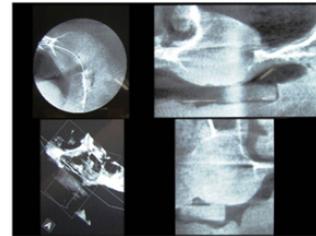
CBCT shows axial, coronal and sagittal section demonstrates the lesion extending into the maxillary sinus.
